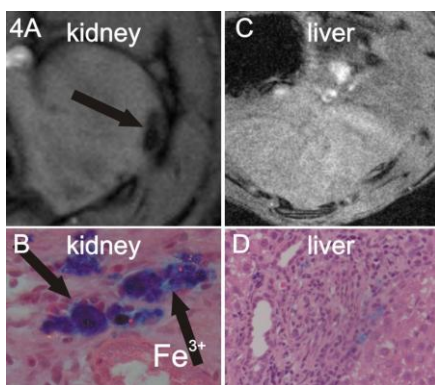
Transplantation site following rejection of allogeneic islets labeled with SPIO particles. A) Persistent MRI signal and B) iron particles beneath the kidney capsule; C) liver without hypointens MRI signal and D) with reduced amount of iron particles.
